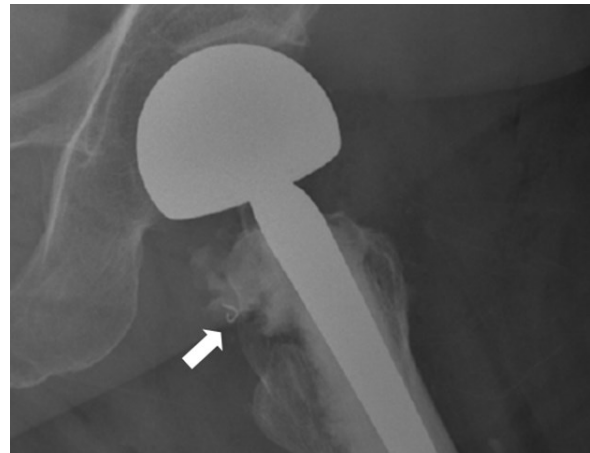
Enlarged image of a plain radiograph (lateral view) showing radio-opaque foreign body. at posterior aspect of the proximal femur. (Click to enlarge)
